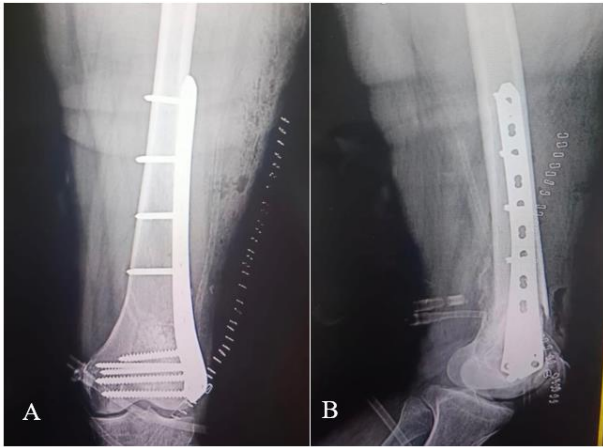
Immediate postoperative (A) AP & (B) lateral x-rays
